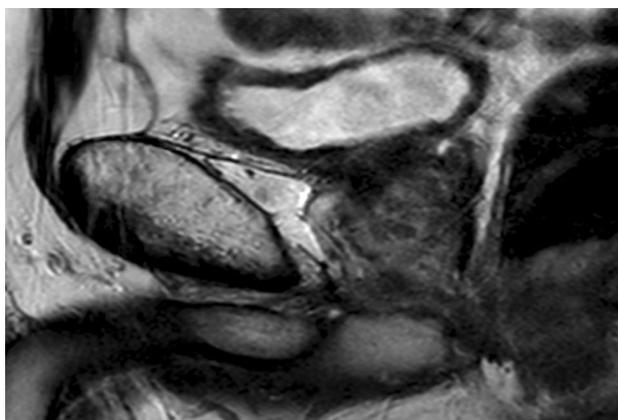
Recto-prostatic plane as assessed by MRI prior to salvage prostatectomy
